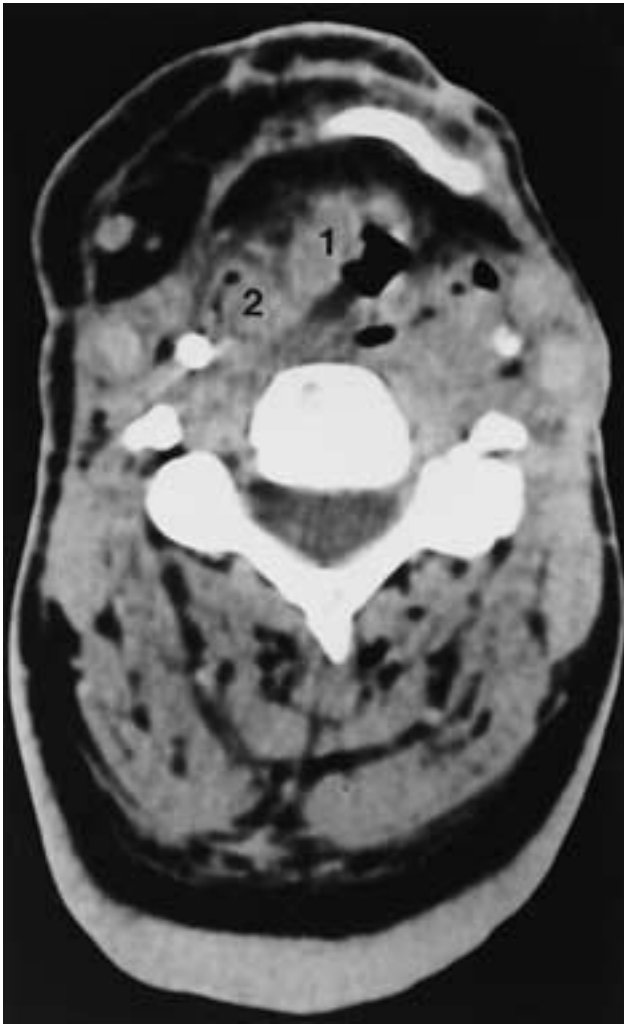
Axial CT shows multiple primary tumors. A patient with previous cancer in the floor of the mouth and radical neck dissection now has three separate primaries in the pharynx-larynx. Scan through the supraglottic level shows an endolaryngeal lesion (1) and a lesion of the pyriform sinus (2). These lesions were not directly connected. The patient also had a lesion of the opposite subglottic region.
